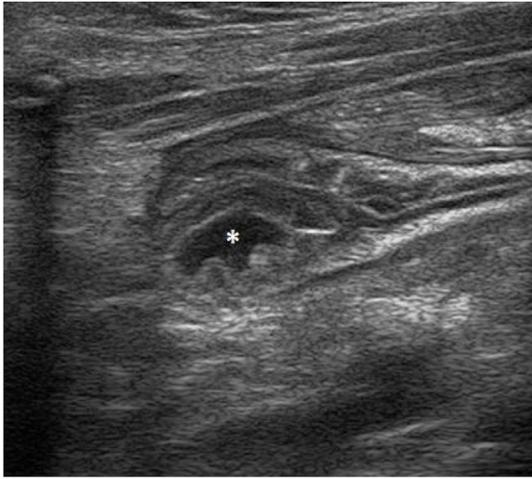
Ultrasound showing in the terminal ileum a small anechoic image (asterisk), probably in the intestinal wall.
